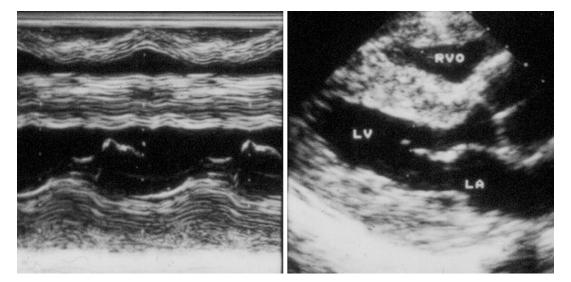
Parasternal long-axis from a patient with cardiac amyloidosis with the corresponding M-mode echocardiogram to demonstrate the reduced left ventricular function. Note again the markedly thickened RV free wall
